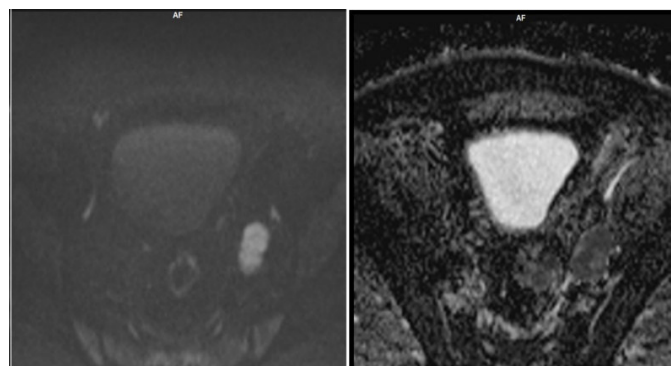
Metastatic lymph node on left showing restriction diffusion on DWI and ADC images.
